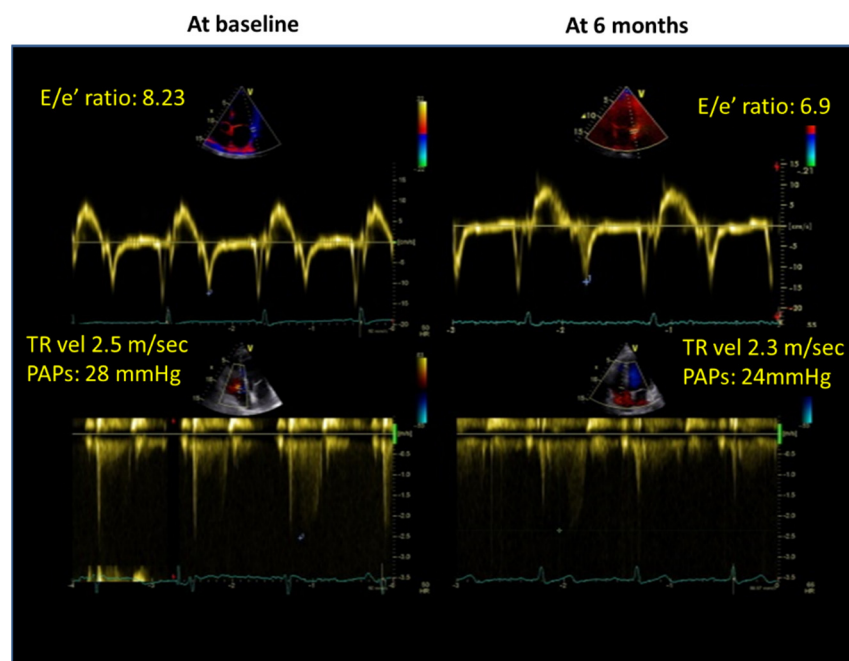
Clinical case of patient undergoing 6 months of tadalafil treatment. Patient's diastolic function at baseline (left) panel and after 6 months of treatment (right) panel; from top to bottom: pulsed Doppler velocity on mitral valve, tissue Doppler velocity of the lateral mitral annulus, peak systolic tricuspid jet velocity.
